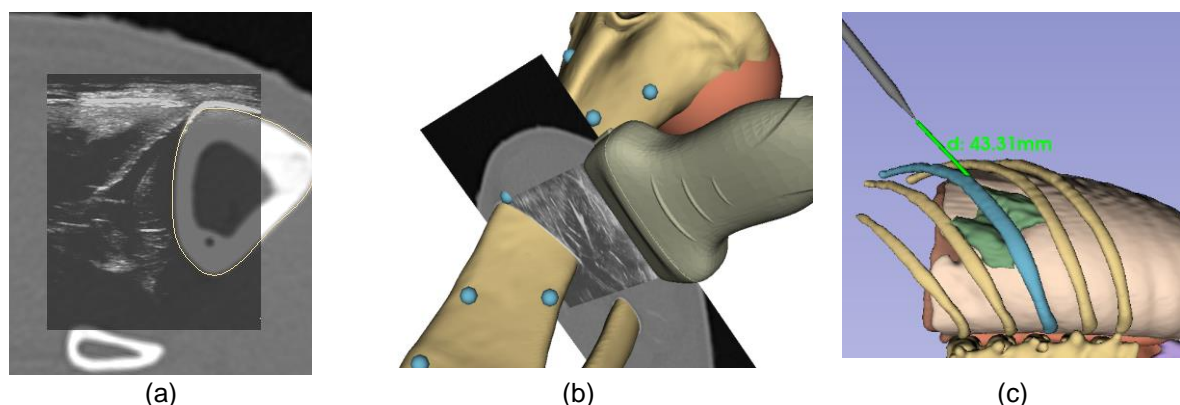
(a) Image fusion between iUS and preoperative derived CT. (b) Intraoperative navigational feedback of patient specific 3D model, surgical planning and the iUS with the superimposed preoperative CT scan. (c) Direct link between surgical pointer and surgical target during the resection of an Ewing Sarcoma in the thoracic wall.
